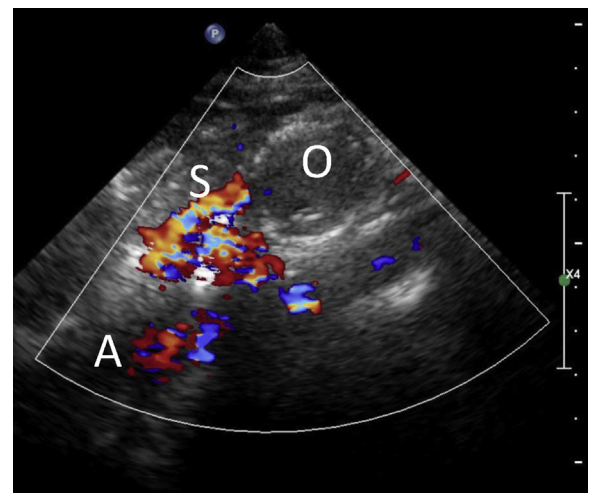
Ultrasound scan depicting thrombosed aneurysm, with aortic and superior mesenteric flow. A, Aorta; O, occluded aneurysm; S, superior mesenteric artery.
